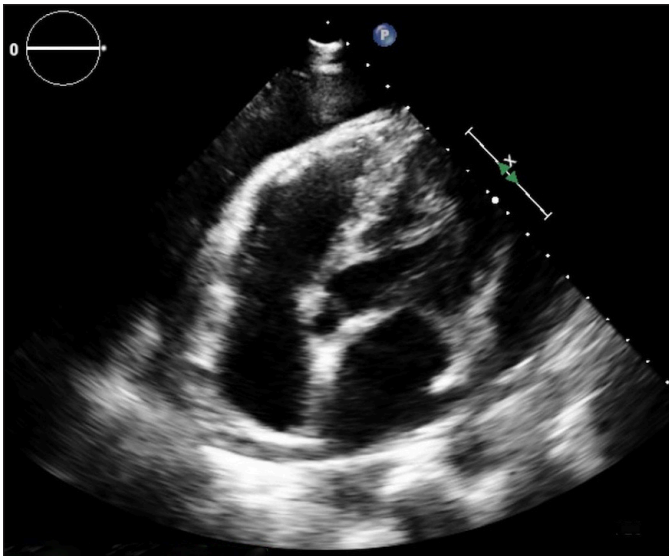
Echocardiogram showing a normal left ventricle with normal wall thickness and an ejection fraction of 55%. A large pericardial effusion with diastolic right atrial collapse is seen.
